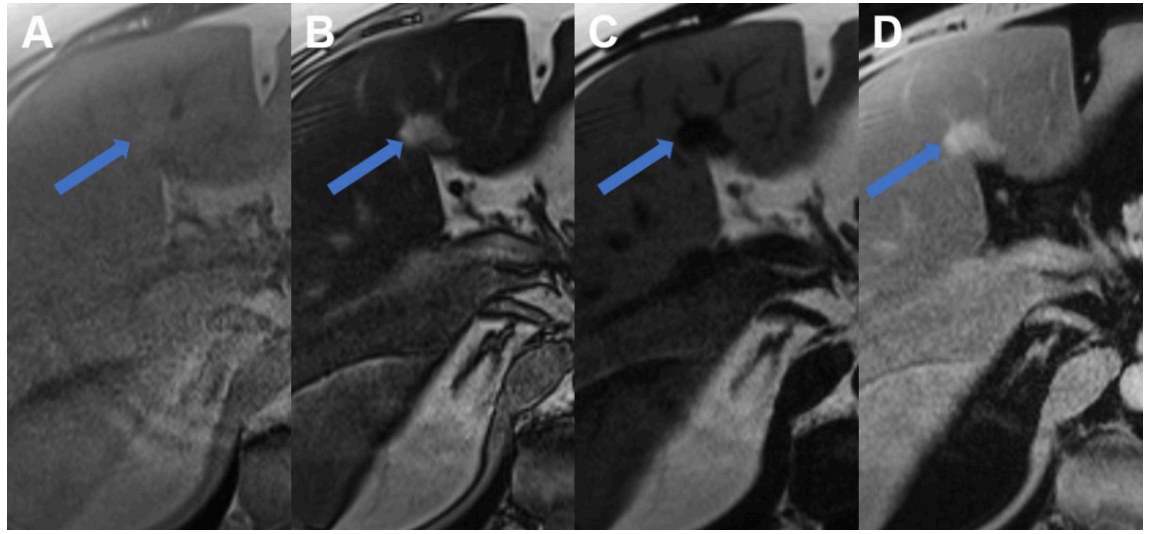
Regional fatty sparing and focal steatosis on MRI. A MRI T1 weighted image of a case with focal sparing (arrow) of steatosis in the porta hepatis with B signal drop in the remaining liver on opposed phase images and persisting high signal in the spared area. C On fat only images, the fatty liver shows signal with the spared area appearing dark, while on D the water only image, the spared area is brighter than the steatotic surrounding liver.
